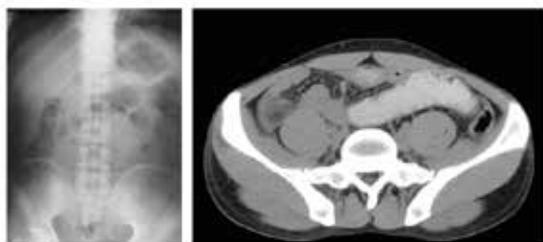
X-ray abdomen erect view showing dilated small bowel loop. CECT abdomen showing dilated jejunal loop
